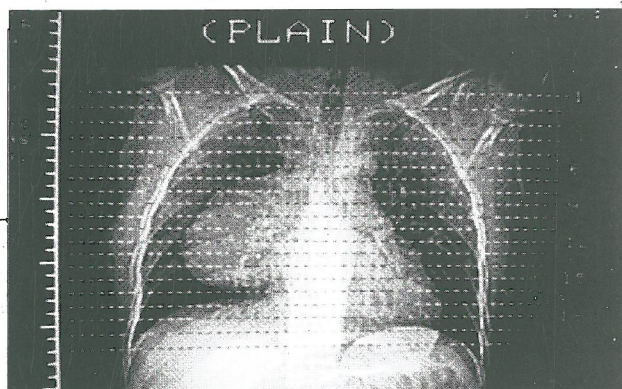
Chest X-Ray shows a right mediastinal mass
